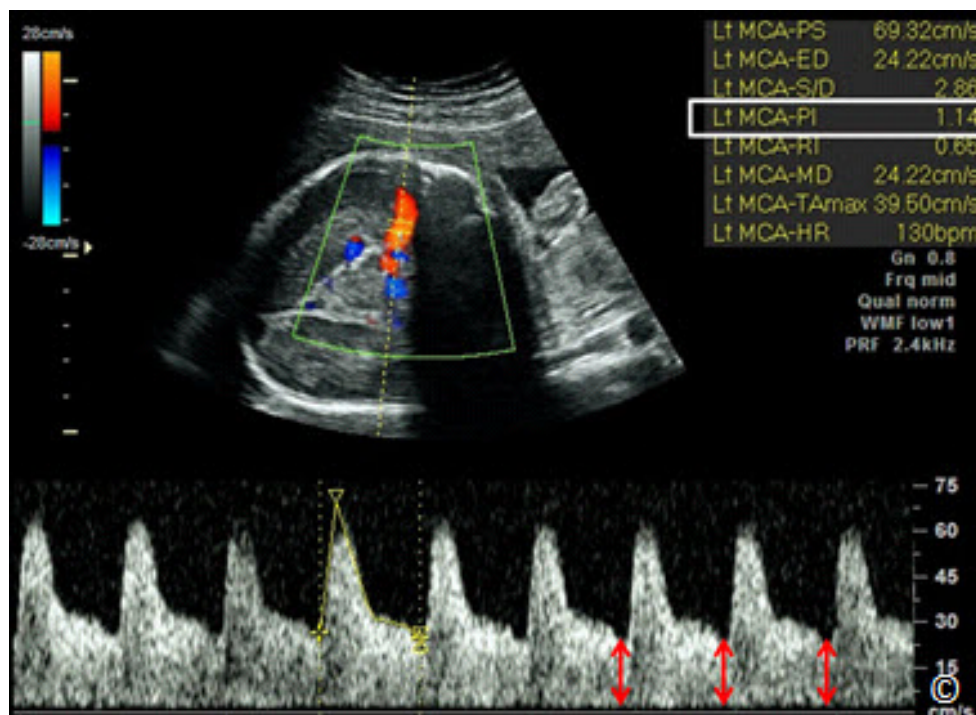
Spectral (Pulse) Doppler of the middle cerebral artery in a growth restricted fetus. Note the low impedance circulation (PI = 1.14) (white rectangle) with increased flow during diastole (red double arrows). This represents brain sparing.
